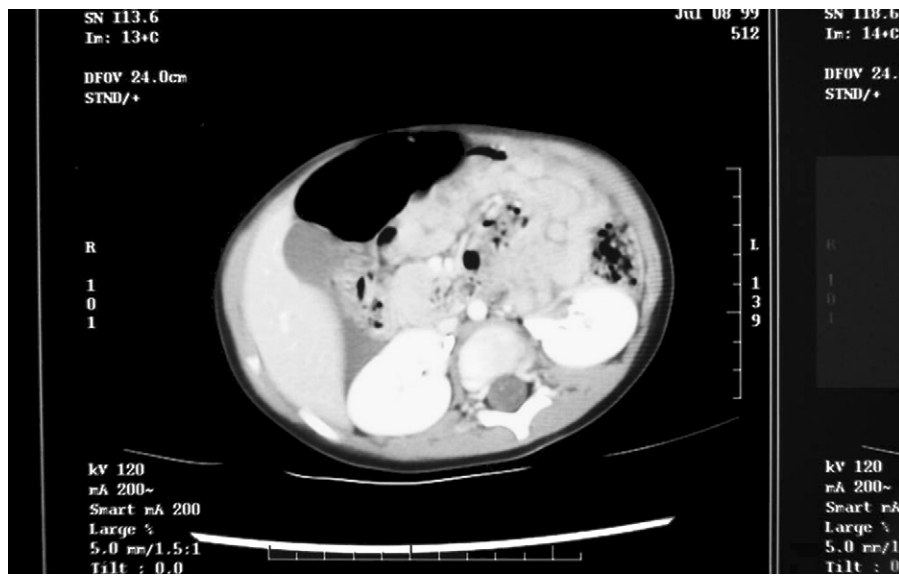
Computed tomography scan showing stool-filled bowel and mesentery between the aorta and superior mesenteric artery, suggestive of an internal hernia.
